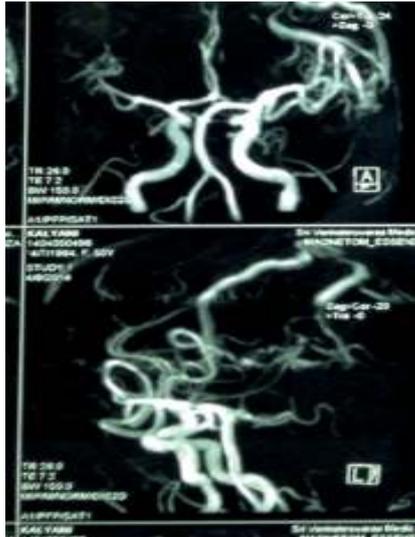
MRI MR-Angio showing Sub Cortical Left Temporal Lobe AVM of size 4.5cms fed by Middle cerebral artery and Posterior cerebral artery and draining veins into Transverse sinus, no intra-nidal aneurysm seen (Grade III AVM).
